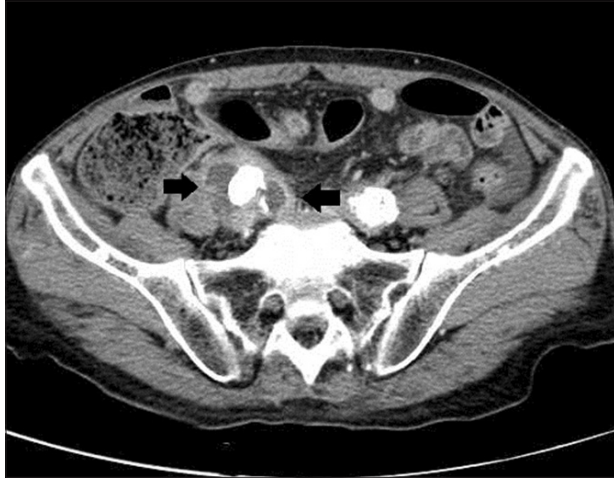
Perigraft fluid collection on post-endovascular aneurysm repair computed tomography.
